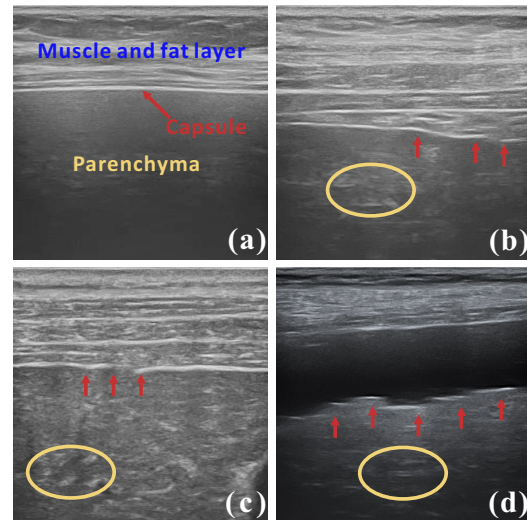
Sample ultrasound images of (a). normal; (b). mild; (c). moderate; (d). severe cirrhosis liver. The red arrows point out the capsule irregularities, the yellow ellipses show the irregular texture of parenchyma, both caused by cirrhosis.
